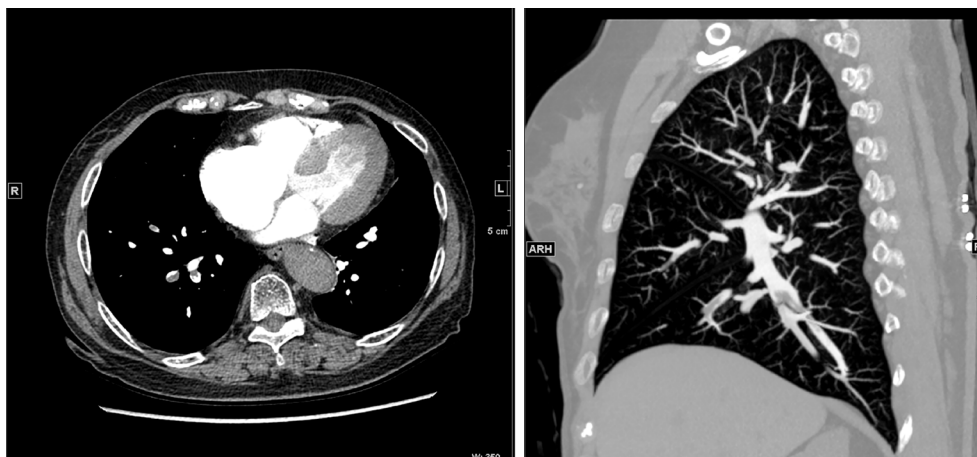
Pulmonary artery CTA. Multiple filling defects at the distal end of the right pulmonary trunk, the distal end of the right upper pulmonary artery, the proximal end of each segment of the arteries, the dorsal segment of the right lower lung, the proximal branch of the basal segment of the artery, and the distal end of the basal segment of the left lower lobe. CTA, computed tomography angiography; L, left side; R, right side; ARH, anterior right horizon.
